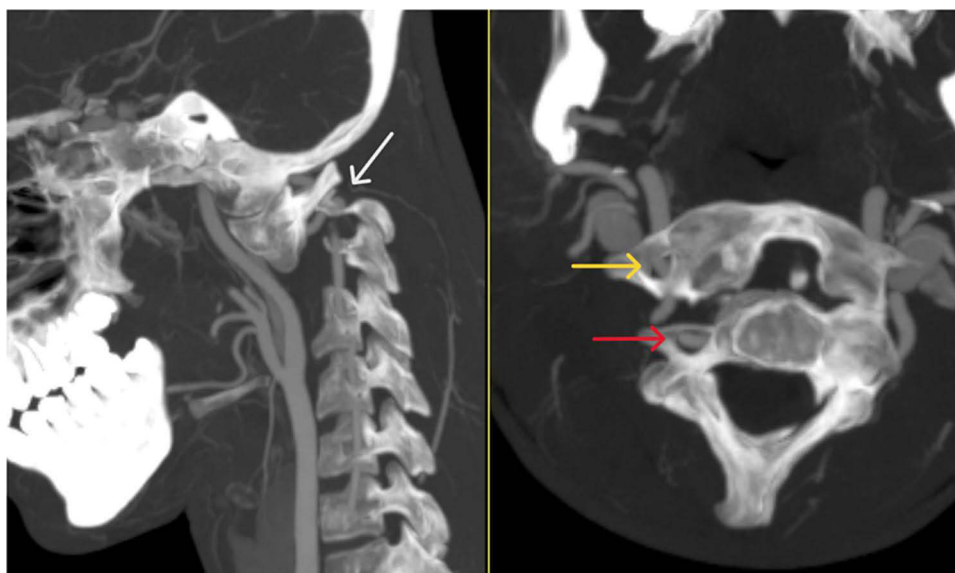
Preoperative CT angiography of the vertebral and carotid arteries, showing no malformation, thrombosis, dissection or pseudoaneurysm. The white arrow in the left side of the picture shows the competency of VA in its atlantoaxial course on the right side. The yellow arrow on the right side of the picture shows the VA in the foramen transversarium of the Atlas and the red arrow shows the VA in the same foramen of the Axis.
